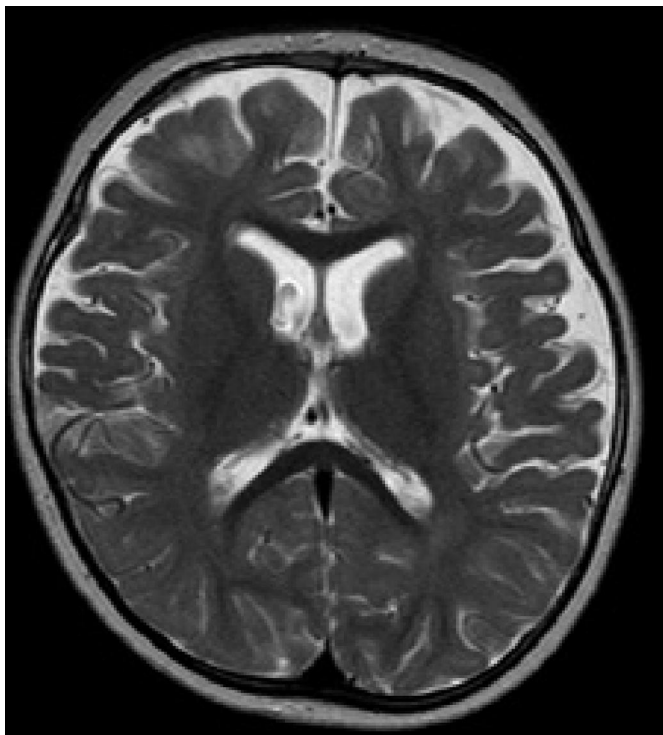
Cranial MRI at level of lateral ventricles indicating bilateral cortical atrophy in the frontal regions and moderate ventriculomegaly.
